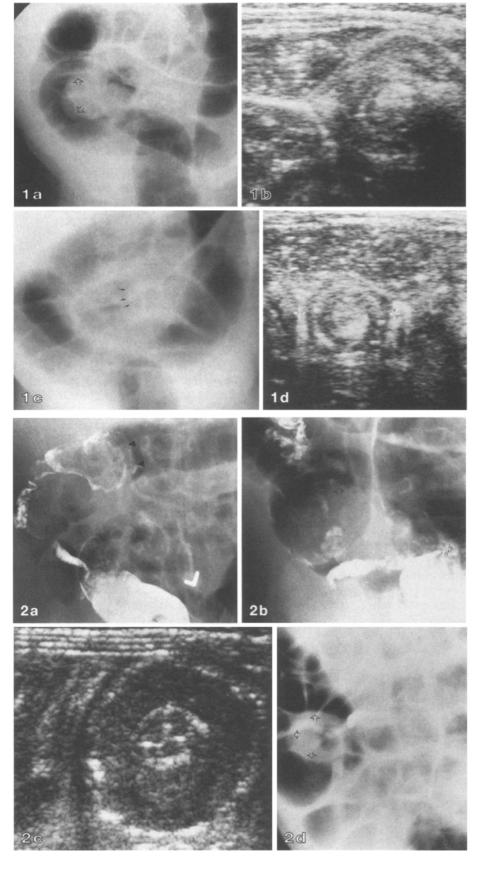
Four-month-old girl with 24-h history of abdominal pain, irritability and blood per rectum. a Initial air enema showing an intussusception (arrows) at the level of the ileocaecal valve, as a soft tissue mass outlined by air. b Sonography 3 h later showing persistence of the large bowel intussusception, on cross section, identified in the right iliac fossa as a large doughnut lesion. c Repeat air enema after the sonogram showing reflux into the terminal ileum and outlining a residual small bowel intussusception (arrows) in the terminal ileum. d Sonography 3 h after the second air enema showing a small bowel intussusception, on cross section, in the right lower quadrant, which was subsequently reduced successfully with air
